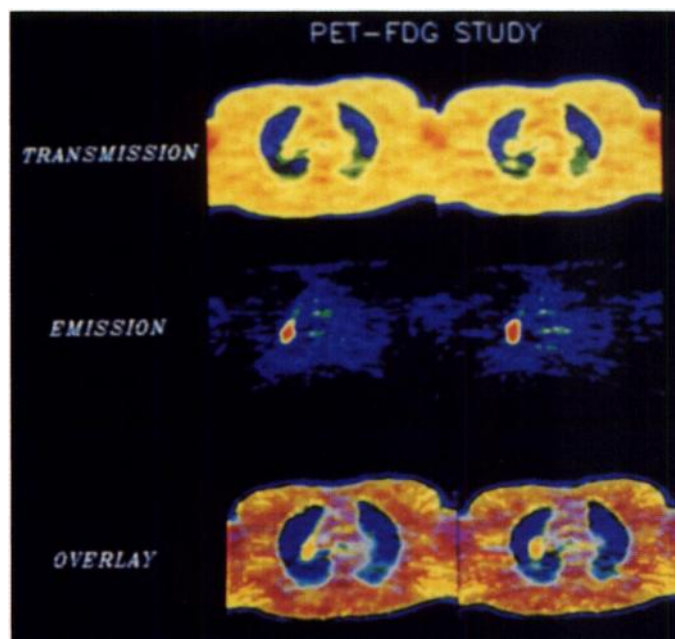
FDG-PET (A) and CT (B) scans (transverse views) in a 50-yr-old woman with a 2.0 × 1.5-cm right lung nodule (adenocarcinoma at thoracotomy). There is intense FDG uptake in the nodule seen on emission images.
